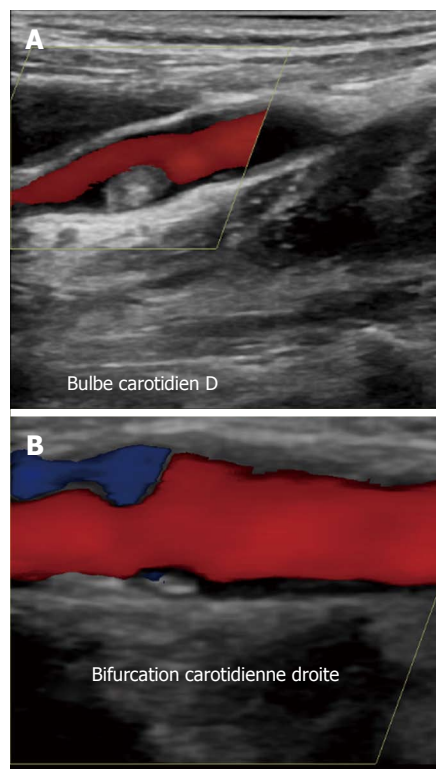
Cervical ultrasonographies in case 2, showing thrombus in the right internal carotid (A) and resorption of this with tiny plaque (B) after 1 wk of treatment.
